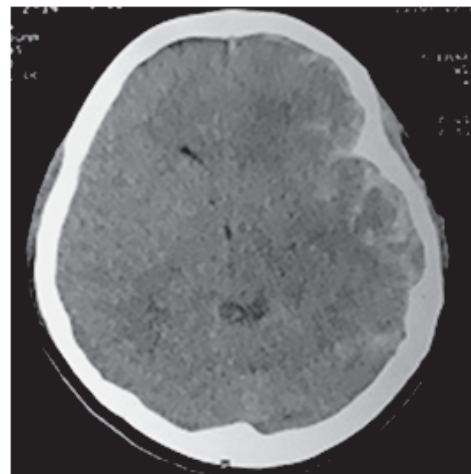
CT scan of head on admission
